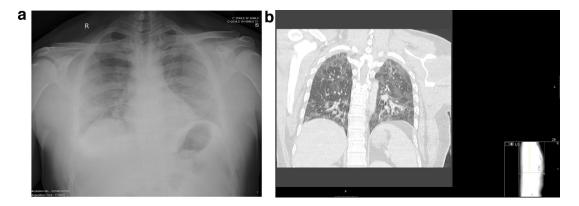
Chest x-ray (A) and thoracic CT (B) performed at admission at our hospital show typical findings of COVID-19 pneumonia, namely bilateral peripheral ground glass opacities with greater involvement of the lower lobes.
